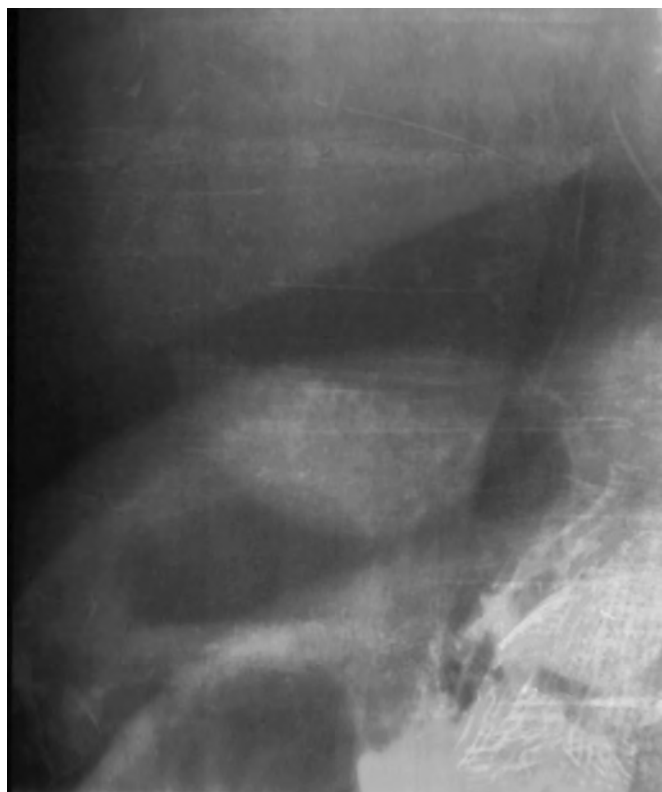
Milk of calcium gallbladder. Calcium carbonate layers dependently on this upright radiograph.
